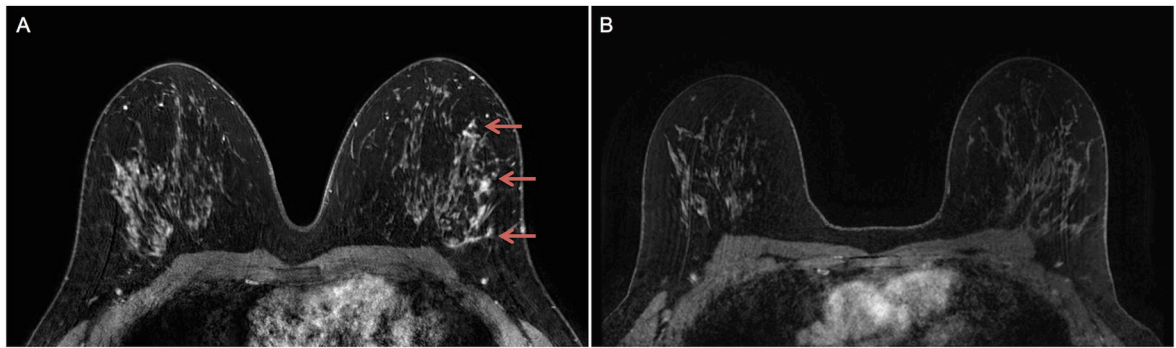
Same-patient initial post-contrast T1-weighted with fat suppression pre-operative MR images at A) 3 tesla (T) and B) 1.5T in a woman diagnosed with high nuclear grade ductal carcinoma in situ (DCIS) by core needle biopsy. Assessed DCIS lesion size at 3T was 59 mm (non-mass enhancement, arrows), while at 1.5T no lesion was described (size = 0 mm). 3T MRI extent better correlated with the final pathology size of 50 mm of high nuclear grade DCIS.
